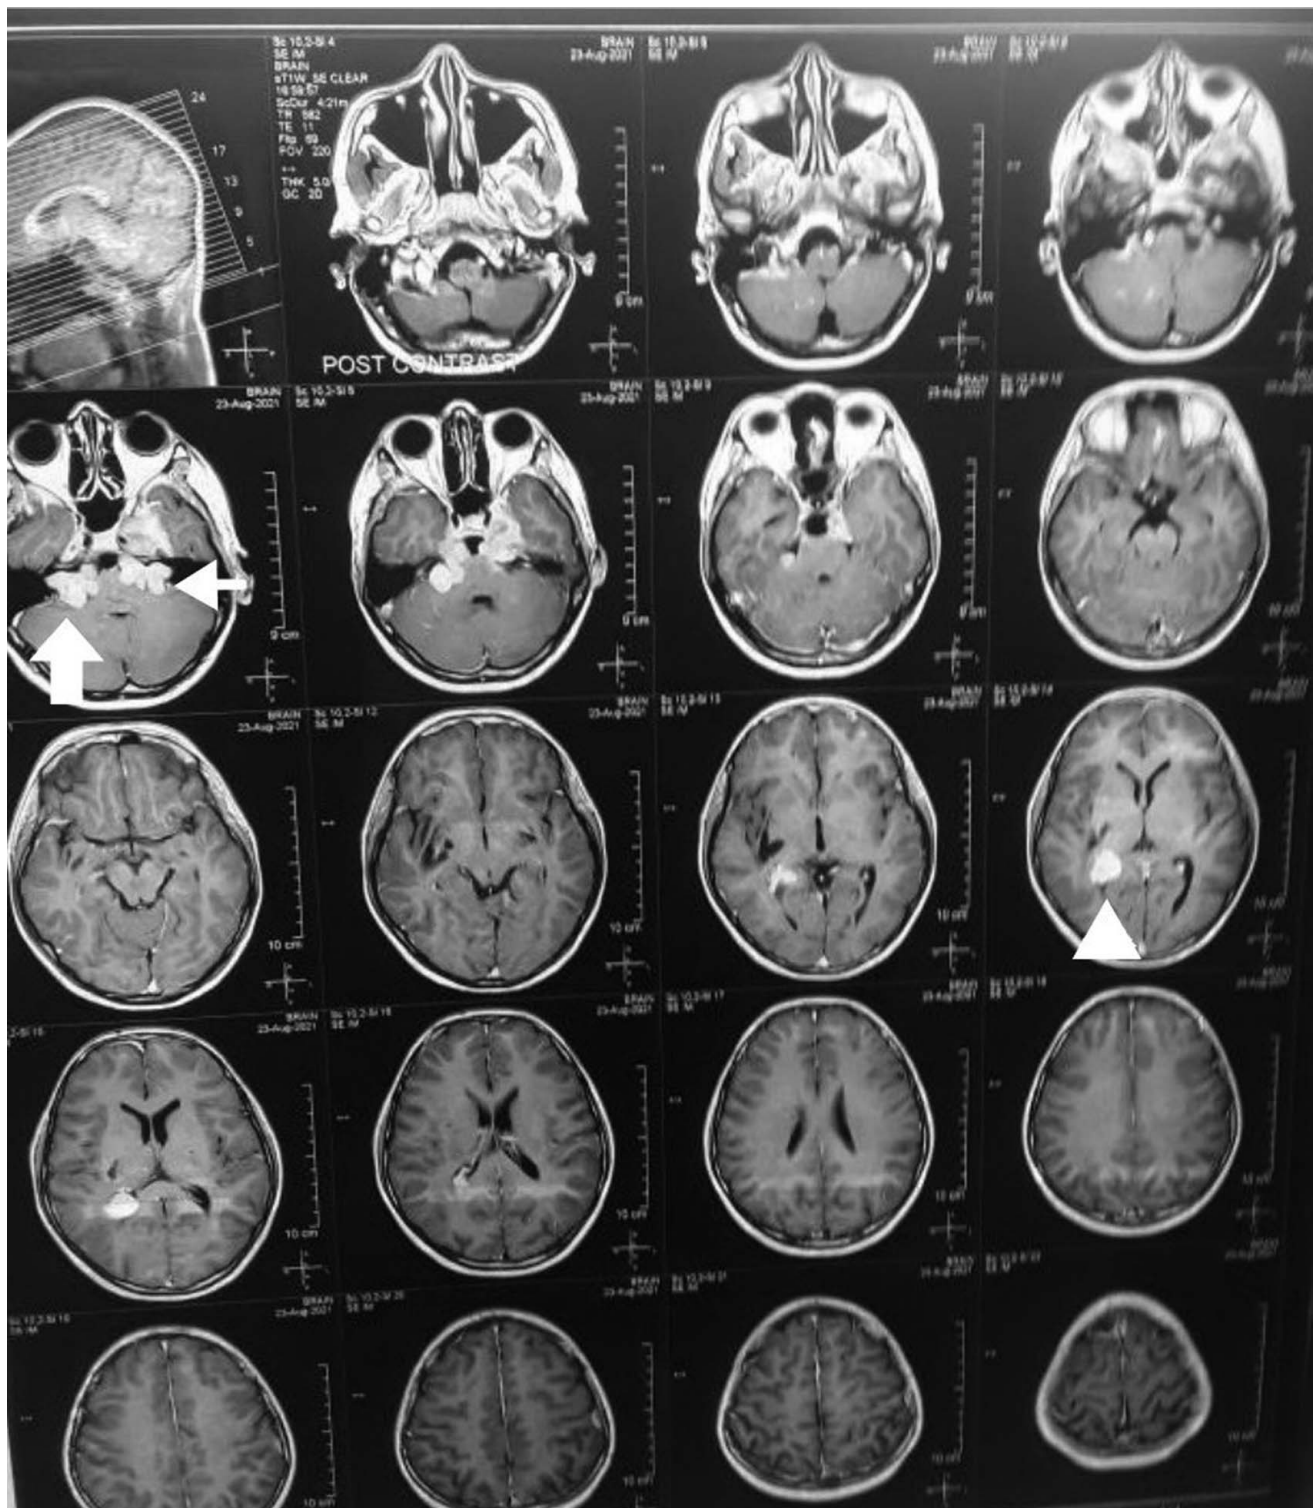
Preoperative MRI of the brain.
